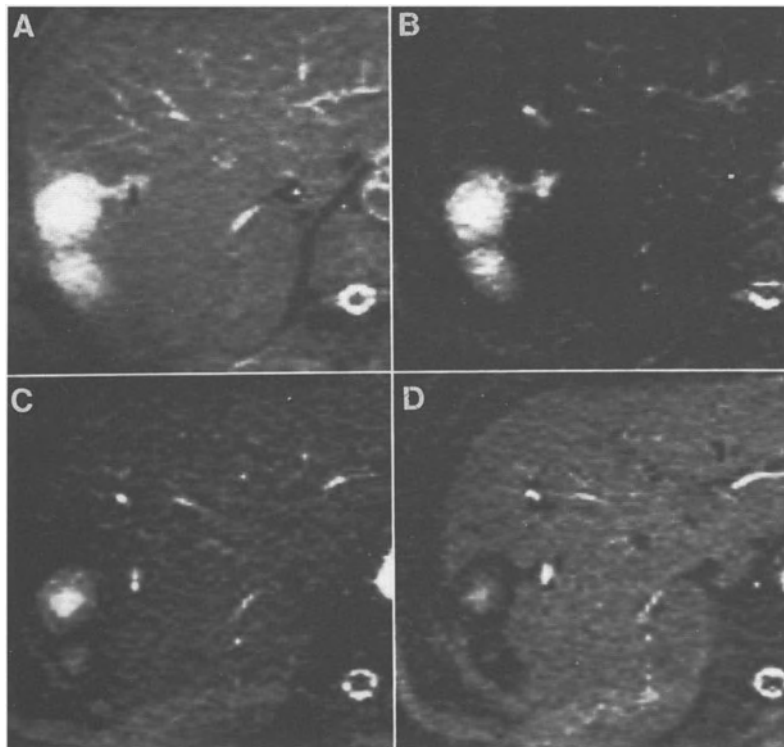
Hemangioma. T2-weighted SE EP-MR images: TR = infinite, TE = 25 (A), 50 (B), 100 (C), and 150 (D) msec. Liver with short T2 shows signal loss at longer TEs in comparison to hemangioma which remains bright because of its longer T2.
